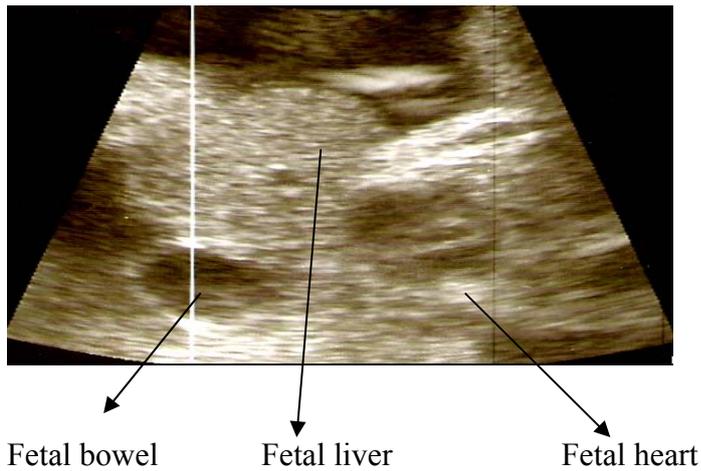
Tranabdominal Ultrasound Showing Fetal Liver, Heart and Bowel Protruding through the Defect
